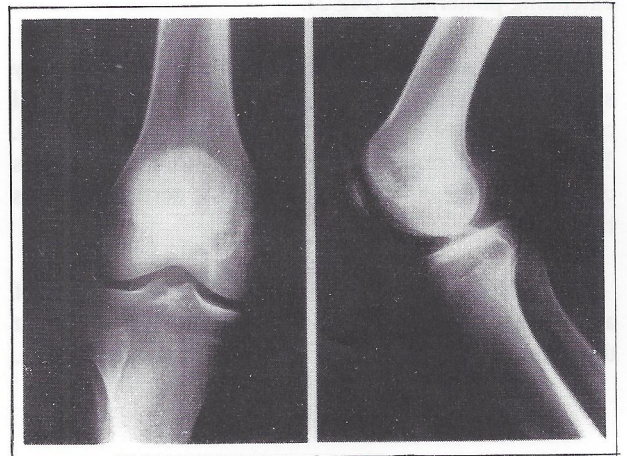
The initial anteroposterior and lateral radiograph of the right knee demonstrating a small intraosseous tumour in the medial femoral condyle, which was overlooked.
